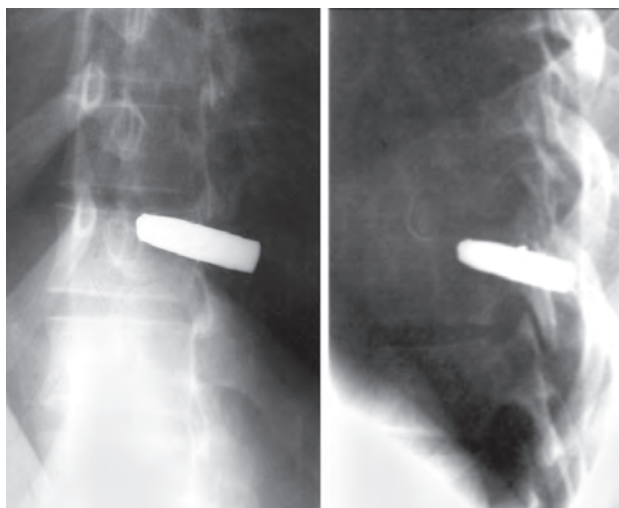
Dorsolumbar spine radiograph showing bullet embedded in the spine
